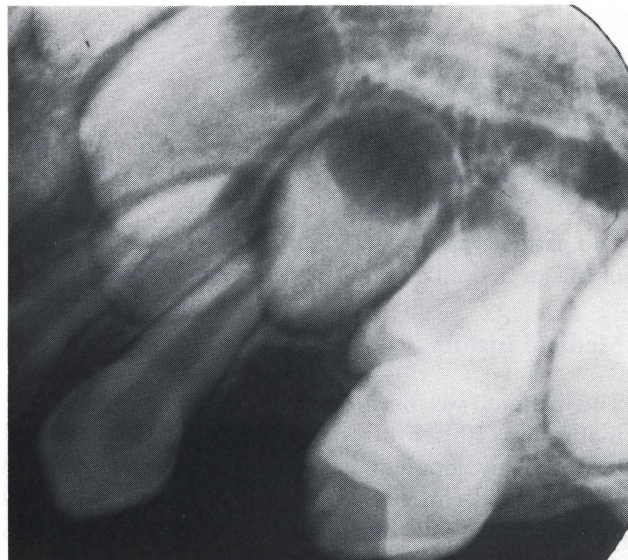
Postoperative occlusal radiograph of affected side showing absence of a developing first premolar and presence of first primary molar.
